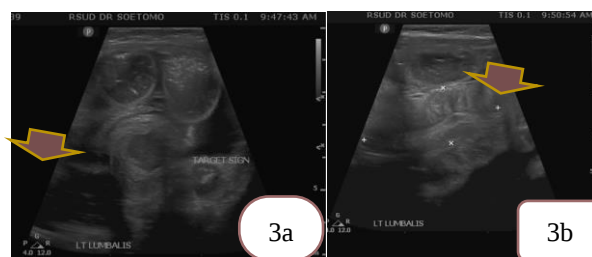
Following ultrasonography examination
